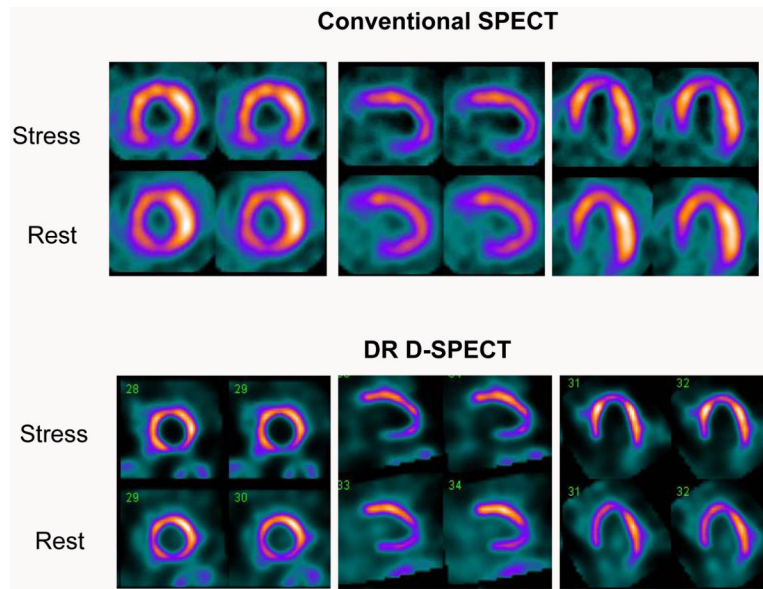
66 year old male with atypical angina and shortness of breath. Known occluded RCA. Conventional SPECT images (top) showed absent uptake in the basal inferior wall and a stress induced infero-apical defect. Rest images showed infero-apical improvement. DR D-SPECT (bottom) showed similar findings. RCA = right coronary artery; DR = dual radionuclide
